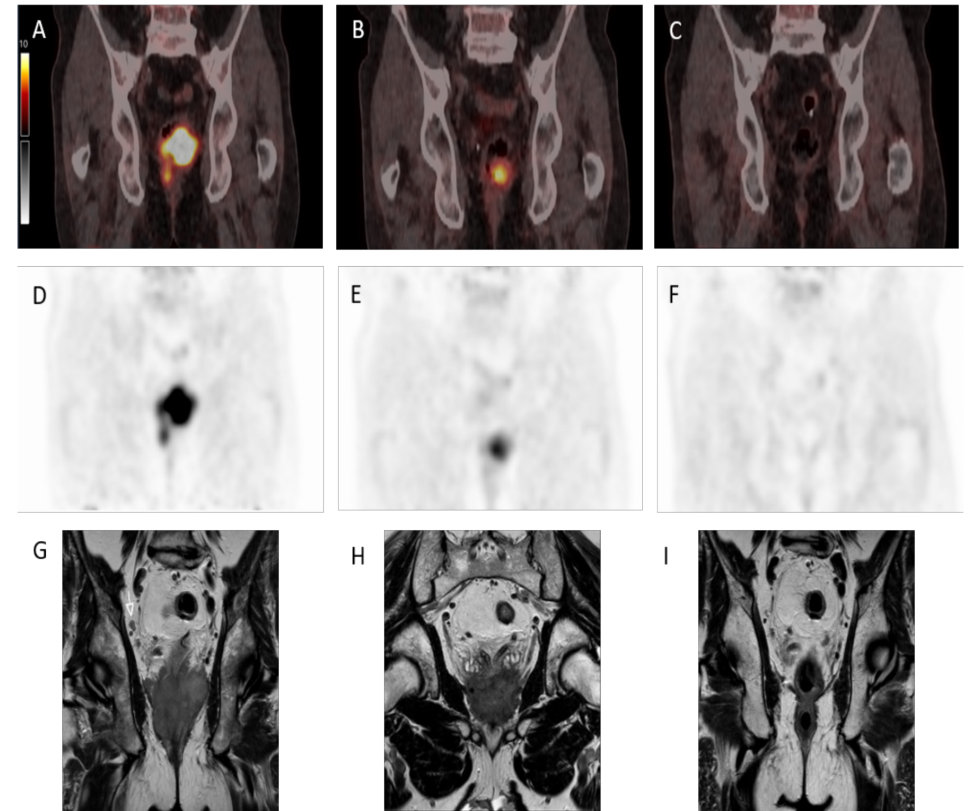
[¹⁸F]FDG PET/CT and T2 weighted MRI images before, during and after neoadjuvant therapy of a patient with a clinical complete response. Sixty-two year old man with cT4bN2M0 rectal cancer had a good response to a yiT1-2N0M0 which further regressed to a yiT0N0M0 six months after chemoradiotherapy, and is currently still followed in the Watch-and-Wait after 12 months of recurrence free follow up. SUV_{max} was 18.1 at baseline, 10.4 at interim assessment, and too low to measure at re-evaluation. Figure shows [¹⁸F]FDG PET/CT fusion (A, B, C) and PET-only (D, E, F) images as well as T2 weighted MRI (G, H, I) images before (A, D, G), during (B, E, H) and after (C, F, I) neoadjuvant chemoradiotherapy.
